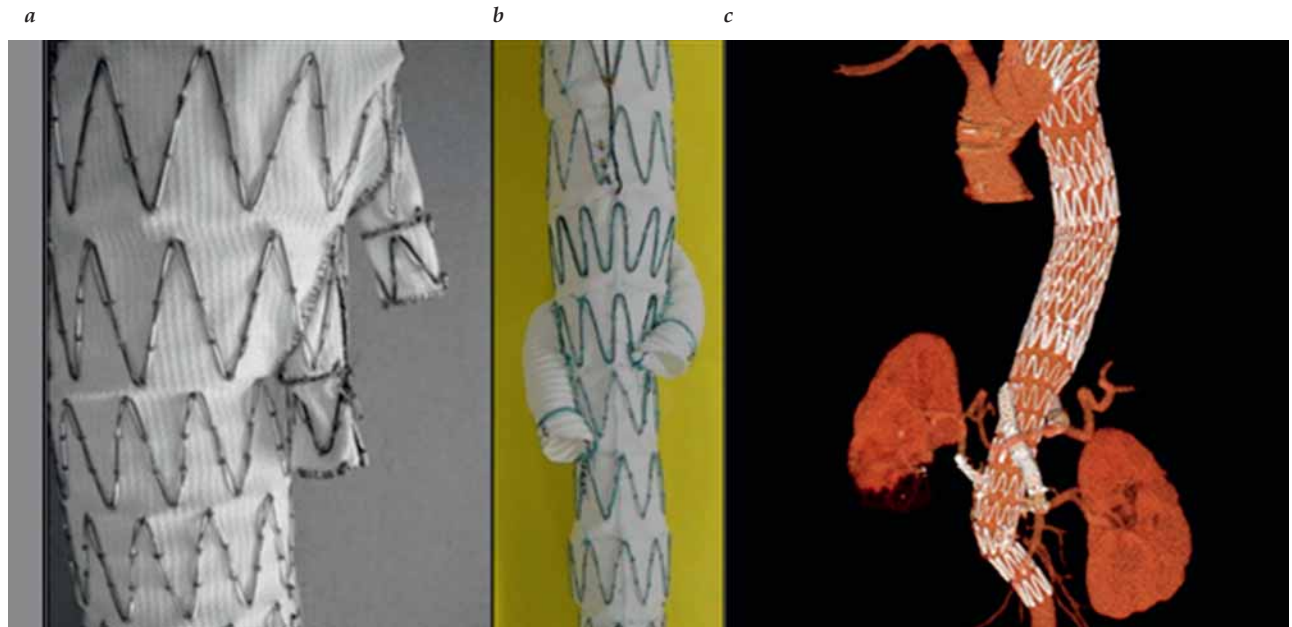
(a and b) Examples of a branched endograft. (c) Reconstruction of a postoperative computed tomographic scan following totally endovascular repair of a type II thoracoabdominal aortic aneurysm.
